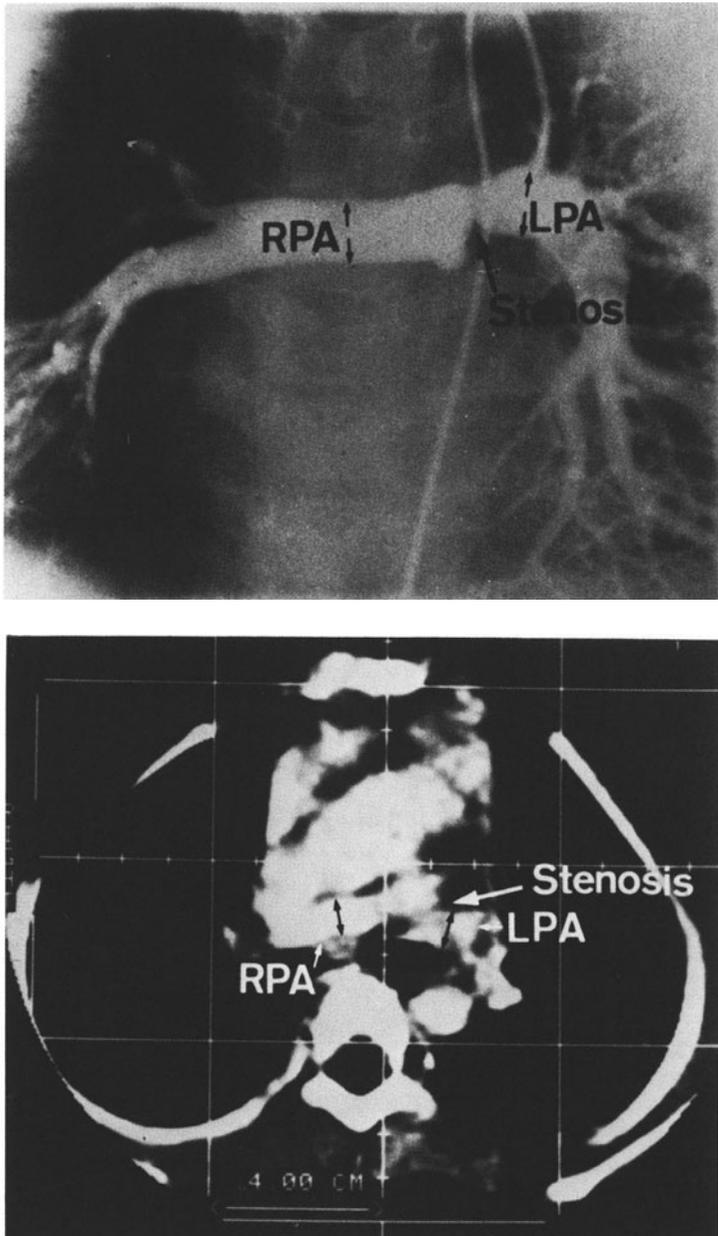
A 3-year-old girl with tetralogy of Fallot and left Blalock-Taussig shunt. Relatively hypoplastic pulmonary arteries and a stenosis of the left pulmonary artery were demonstrated by the pulmonary arterial angiogram obtained with a catheter that was introduced through the Blalock shunt retrogradely. The pulmonary arterial anatomy was readily shown very clearly by CT.
